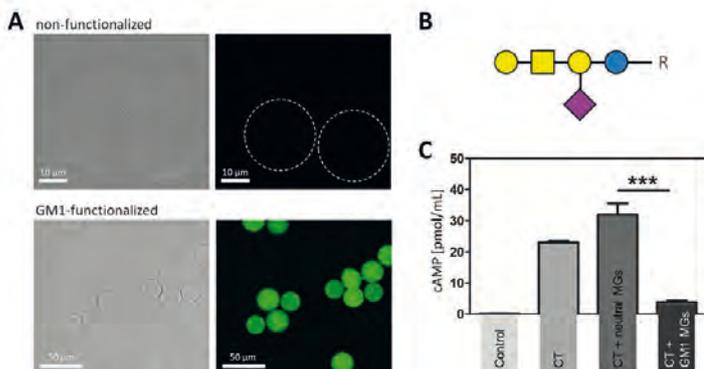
Scavenging of CT by GM1a microgels (MGs). A) Specific binding of fluorescent CT subunit B to GM1a-functionalized microgels; B) GM1a; C) Protective effect of GM1a-functionalized microgels on human cells determined by cAMP concentration.
